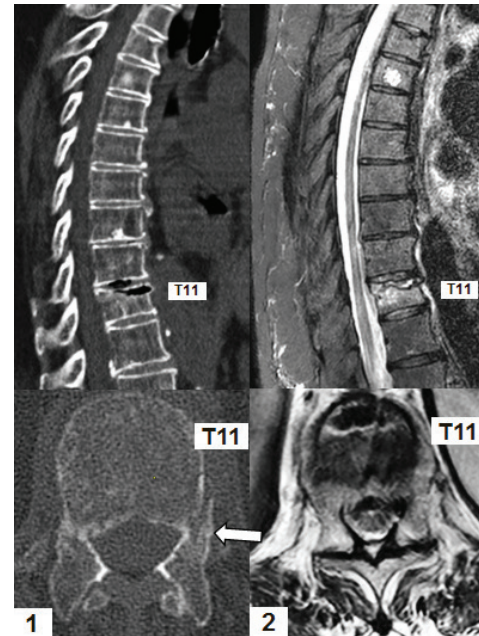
1) Preoperative CT scan evaluations showing a T11 osteoporotic vertebra fracture demonstrating a vacuum cleft sign and superior endplate discontinuity extending to the posterior cortex may be associated with a pedicle fracture indicated with an arrow. 2) Preoperative MRI scan evaluations showing an acute T11 vertebral fracture
